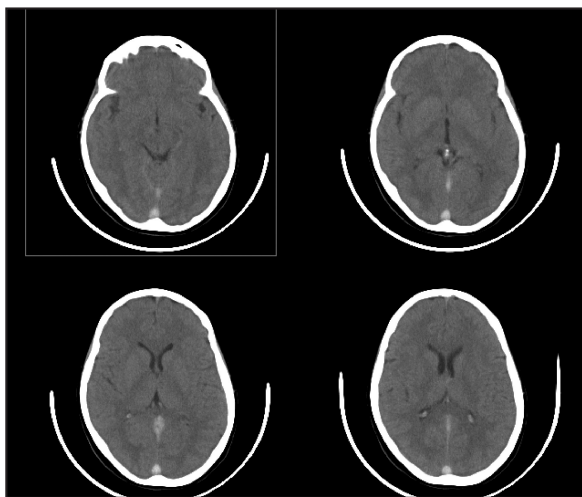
Cranial CT scan: a hyperdense image in the area of the superior longitudinal, straight and transverse sinuses.
